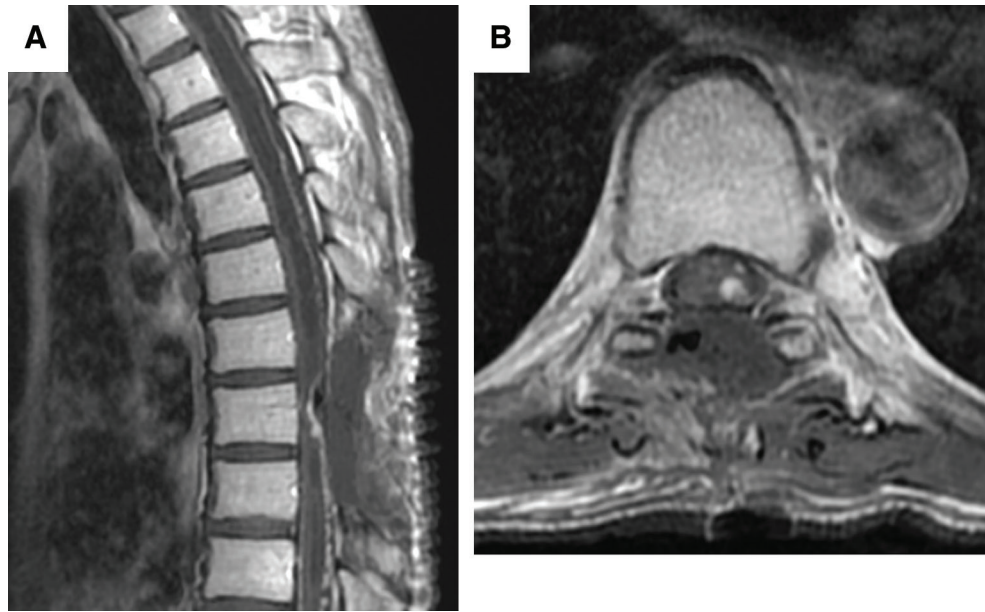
Gd-enhanced MRI of the spinal cord demonstrating a small residual tumor in the Th8 region. (A) A sagittal and (B) an axial image.
